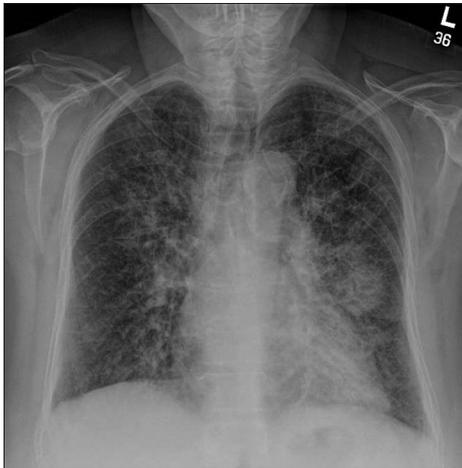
Chest X-ray with evidence of the left upper lobe pneumonia.
